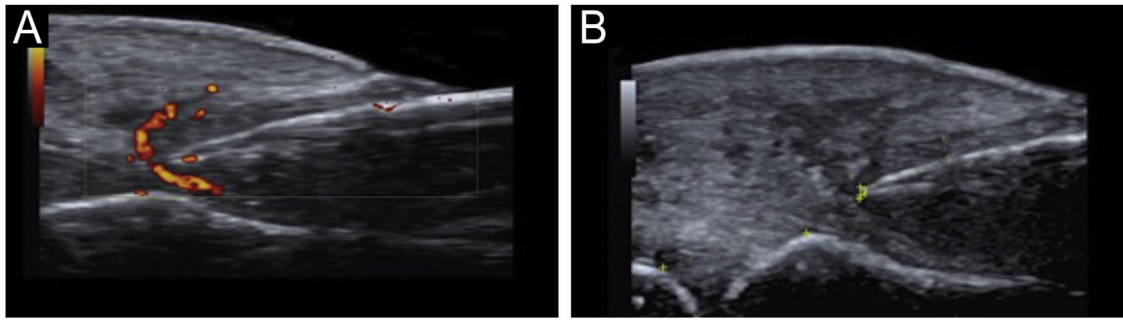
(a) Power Doppler around the nail plate. (b) Visualization of thickening of the nail fold (dermis and hypodermis) of 5 mm.
